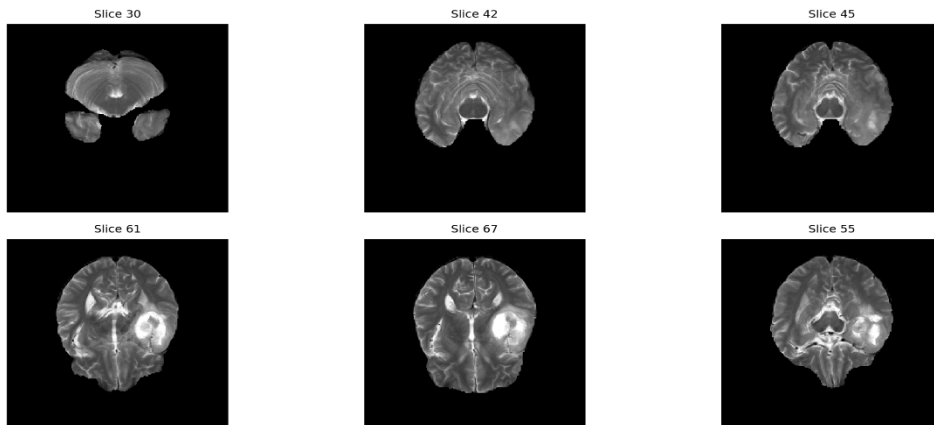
Example of T2-weighted MRI slices from the BraTS 2023 dataset, with different cross-sections of the brain.
